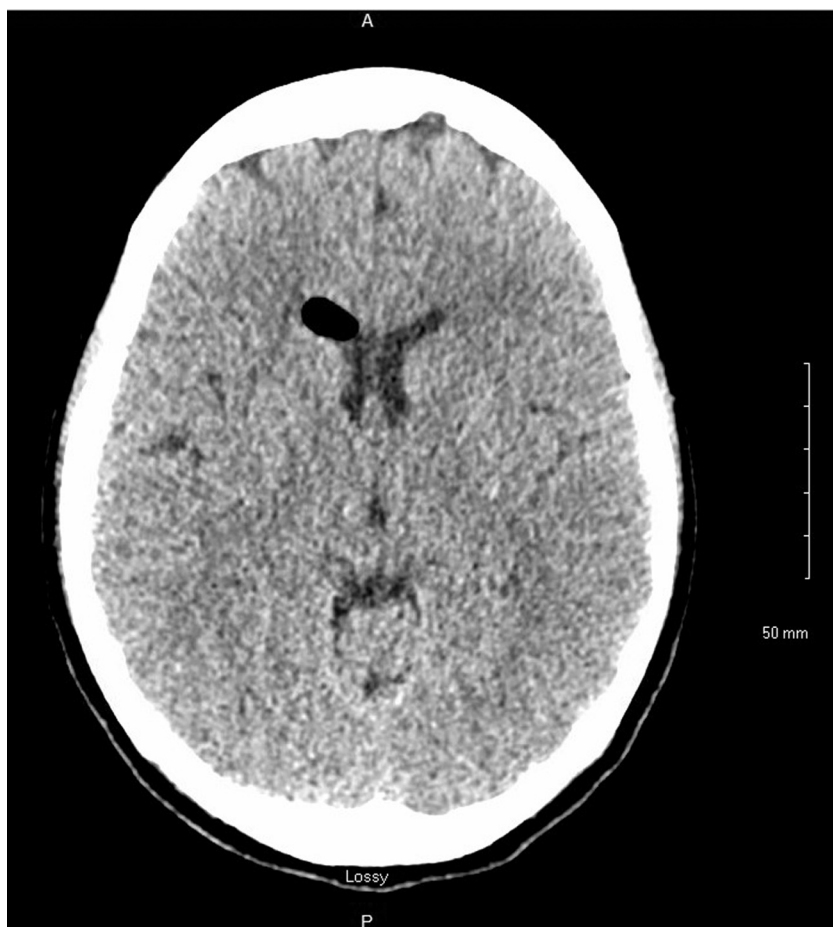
Noncontrast-enhanced computed tomography scan of the head demonstrating the presence of intraventricular gas within the anterior horn of the right lateral ventricles.
